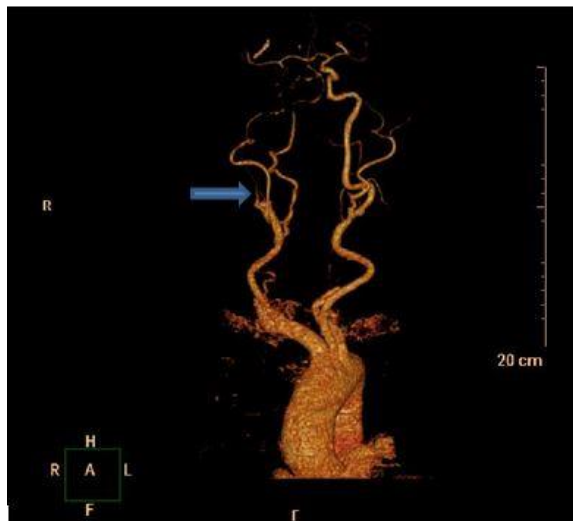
Reconstruction 3D of supra-aortic trunks CTA with stenosis of the right carotid artery (arrow)
